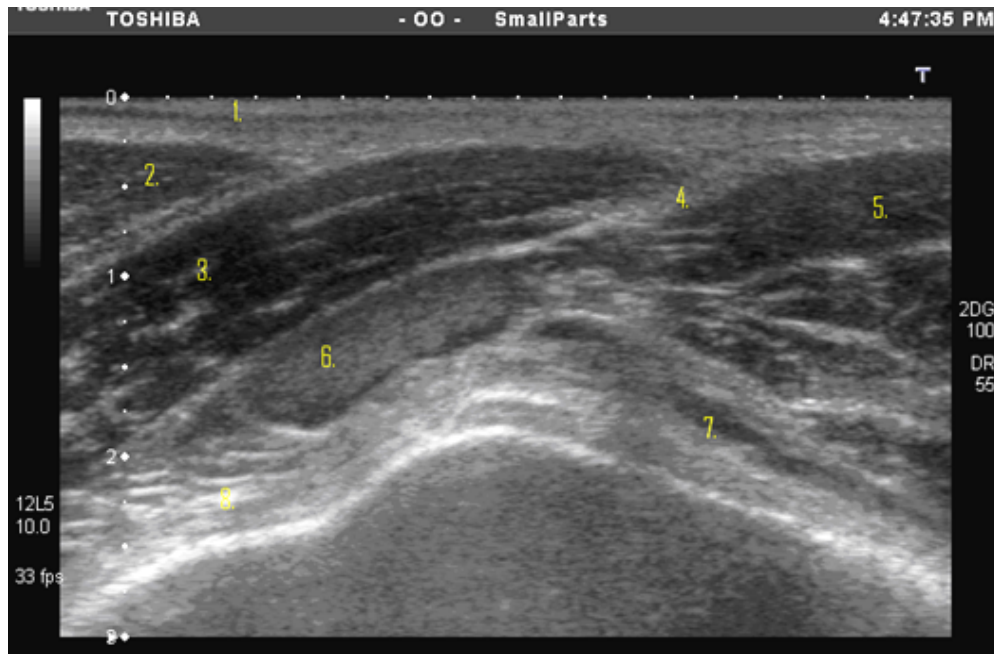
Two-dimensional ultrasonographic appearance and topography of a popliteus lymph node
